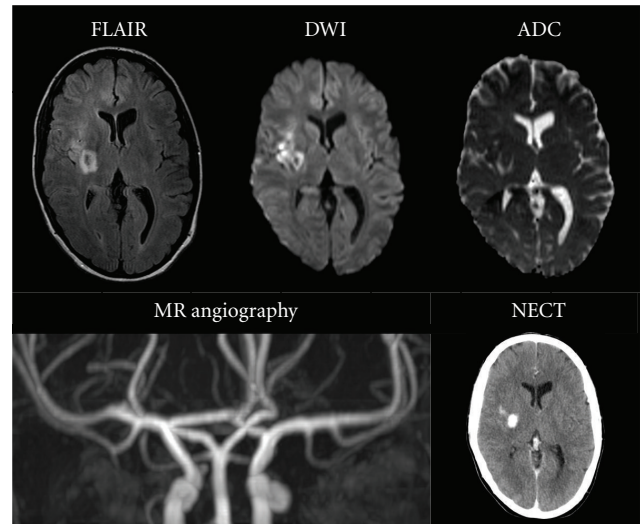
Case 4: follow-up MRI with FLAIR, DWI, ADC showing a relatively small infarction with minor hemorrhage in the right basal ganglia in comparison to the large penumbra seen on the initial CTP examination. The MRA shows complete recanalization of the previously partially revascularized right MCA. NECT shows a small hemorrhagic transformation in the right basal ganglia and parenchymal contrast leakage due to increased permeability secondary to ischemia and neurointervention.
